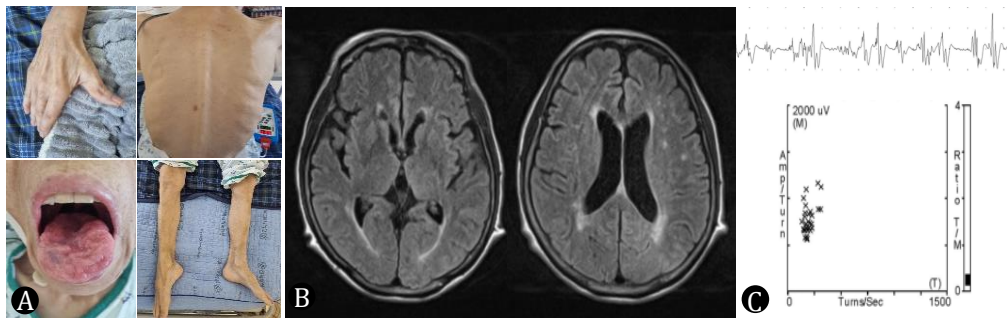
(A) Muscle atrophy in right hand, both legs, and axial muscles and tongue atrophy, (B) Brain MRI, (C) Electrodiagnostic study showing long duration and polyphasic MUAP in deltoid, and neuropathic pattern in turns-amplitude analysis
